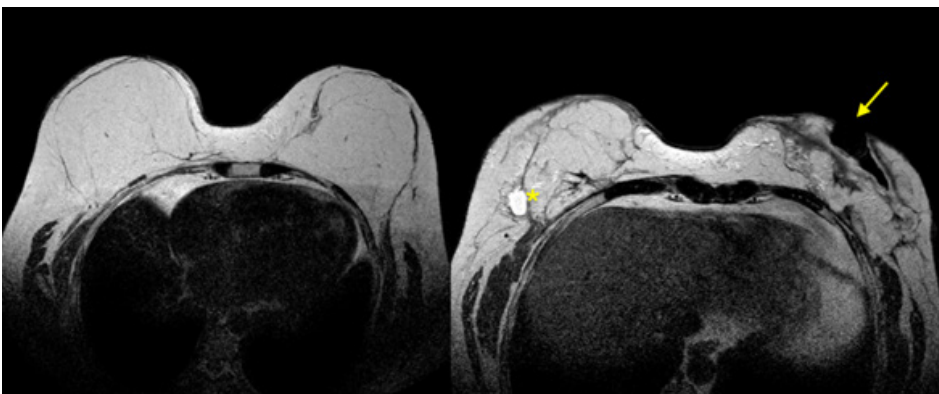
A 55-year-old woman with a history of oncoplastic surgery with rectus abdominis muscle flap (TRAM). The MRI study revealed the presence of a small seroma on the right (asterisk) and the presence of cutaneous necrosis and dehiscence of the left suture (arrow).
